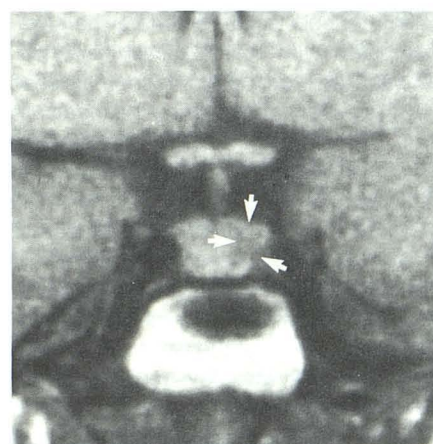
30-year-old woman with Cushing disease. T1-weighted coronal image, 600/20, shows poorly margined left-sided hypointensity measuring 8 mm in diameter (*arrows*) with normal midline stalk. At surgery, low-intensity focus corresponded to left-sided 5-mm ACTH-secreting adenoma. (Left half = true positive; right half = true negative.)
